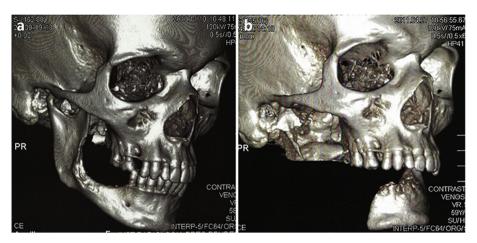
(a) Pre-operative CT scan; (b) CT scan after the surgical resection.
